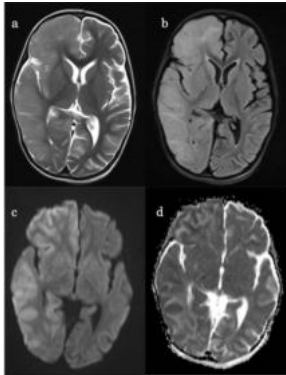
MRI Brain showing T2/FLAIR hyperintensity , gyral swelling and effacement of sulci in right cerebral hemisphere on T2WI (a) , FLAIR axial image (b) along with diffusion restriction on diffusion weighted images (c & d) .
